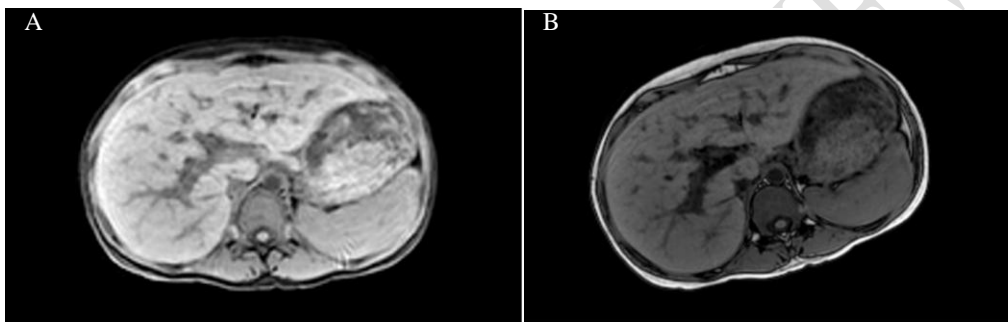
MRI MRCP report
